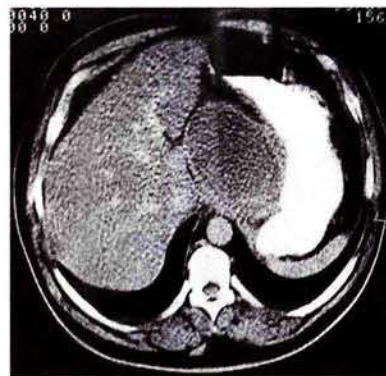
Appearance of the cystic mass in computed tomography.
